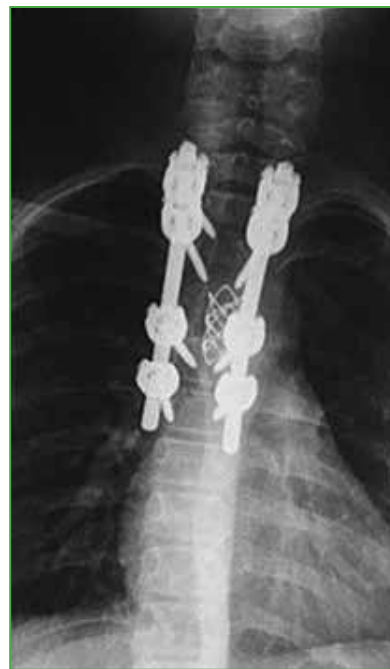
Postoperative anteroposterior radiograph of the cervical and proximal thoracic spine. Pedicle fixation from T2 to T6 and placement of a titanium interbody cage with bone graft are seen.
